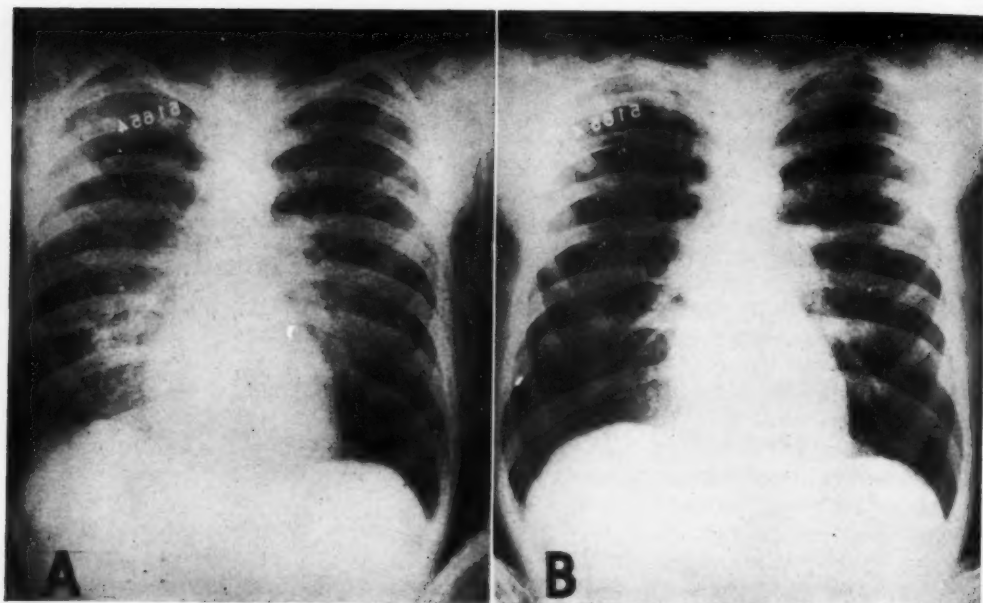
Case 2: A. Admission roentgenogram showing miliary shadows, especially in the hilar zones. B. Disappearance of lesions following potassium iodide therapy.
